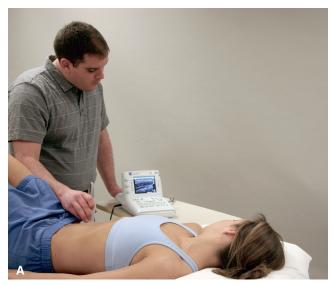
(A, B) Use of rehabilitative ultrasound imaging provides augmented (visual) feedback on the screen during exercise instruction to help the patient learn how to activate the transversus abdominis and internal oblique muscles.
